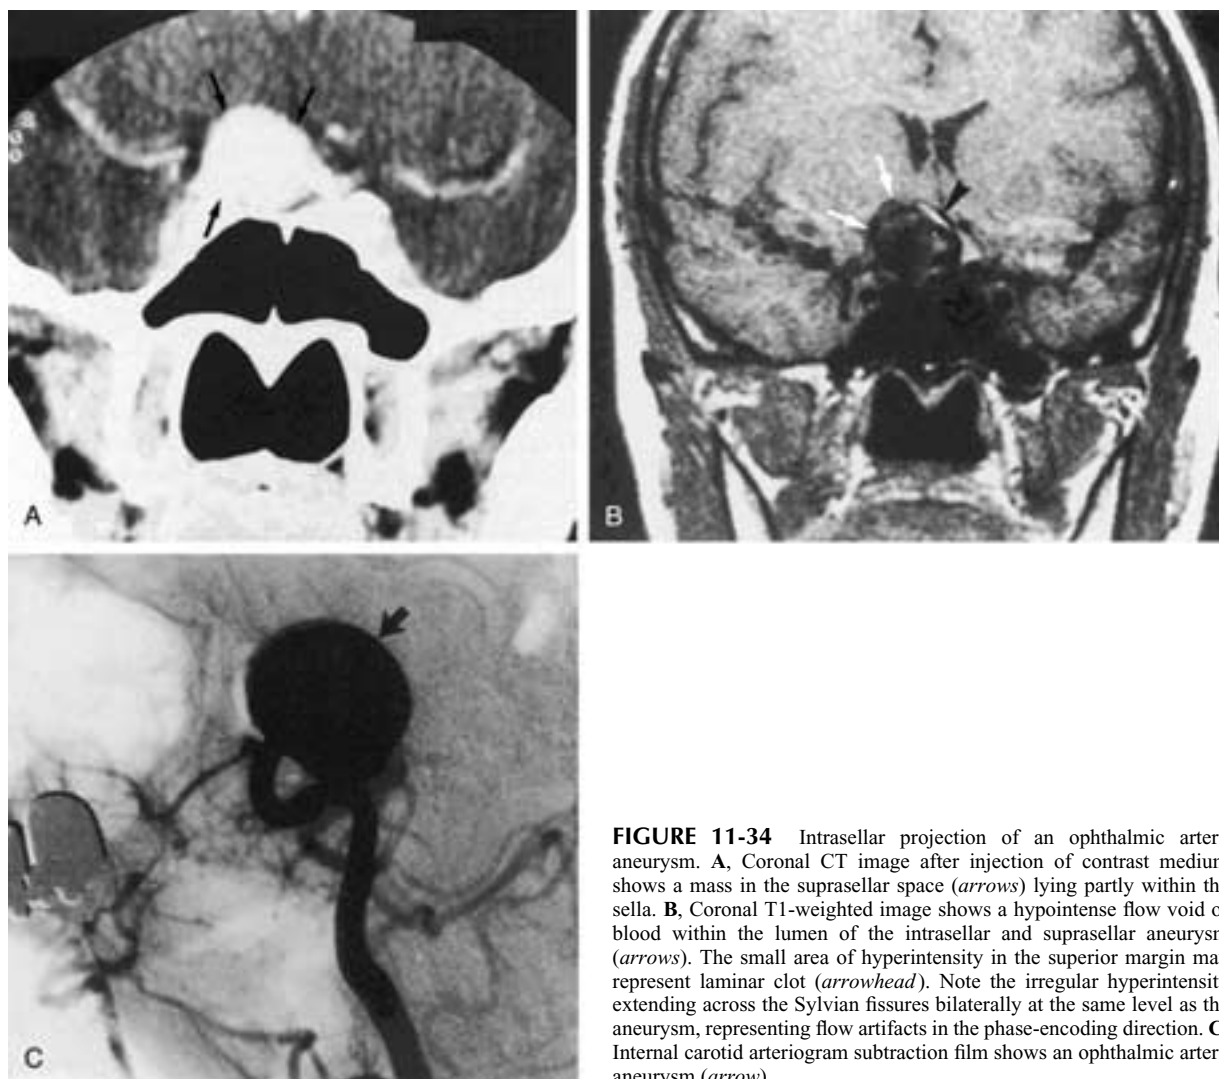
Intrasellar projection of an ophthalmic artery aneurysm. A, Coronal CT image after injection of contrast medium shows a mass in the suprasellar space (arrows) lying partly within the sella. B, Coronal T1-weighted image shows a hypointense flow void of blood within the lumen of the intrasellar and suprasellar aneurysm (arrows). The small area of hyperintensity in the superior margin may represent laminar clot (arrowhead). Note the irregular hyperintensity extending across the Sylvian fissures bilaterally at the same level as the aneurysm, representing flow artifacts in the phase-encoding direction. C, Internal carotid arteriogram subtraction film shows an ophthalmic artery aneurysm (arrow).
